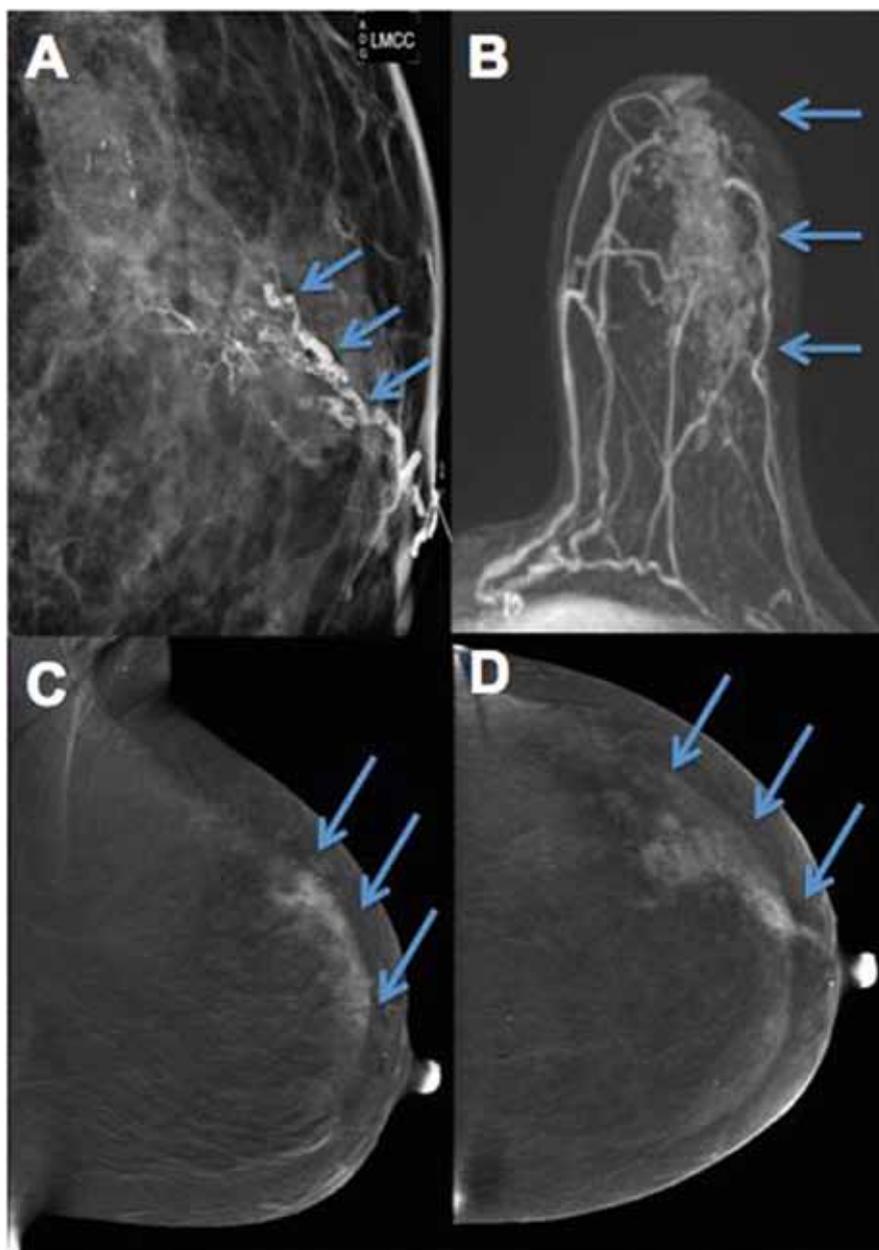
A 43 year-old woman presented for spontaneous bloody left nipple discharge. After inconclusive diagnostic imaging evaluation including mammography and breast ultrasound (not shown), ductography showed multiple irregular filling defects within medium-sized ducts (A, arrows). The patient underwent contrast-enhanced breast MRI and spectral mammography. Both MRI (B, arrows) and CEsM (C and D, arrows) show clumped non-mass enhancement in a segmental distribution in the upper outer quadrant of the left breast. MRI-guided core needle biopsy showed ductal carcinoma in situ.
